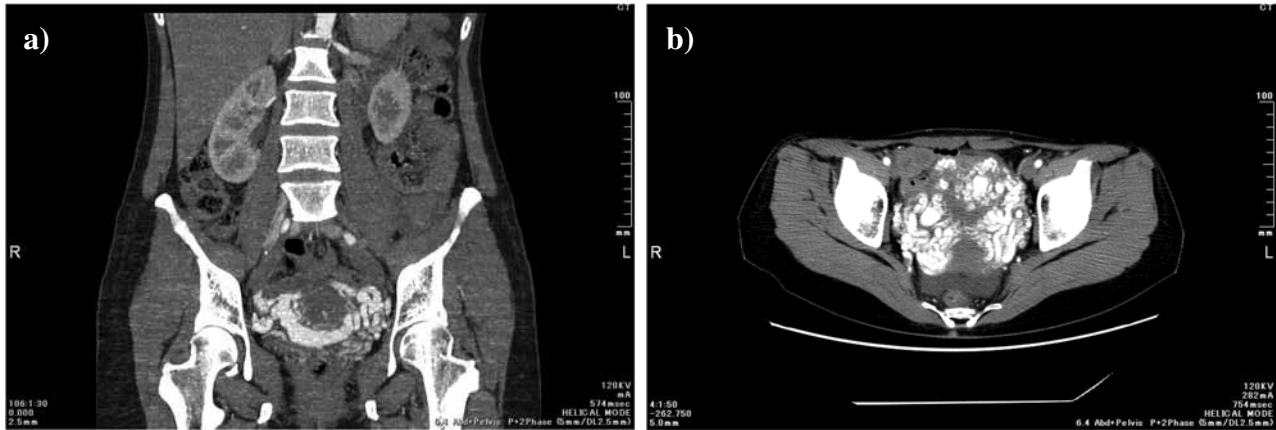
Bilateral hypervascular mass shown by enhanced CT. a) coronal section; b) horizontal section.
